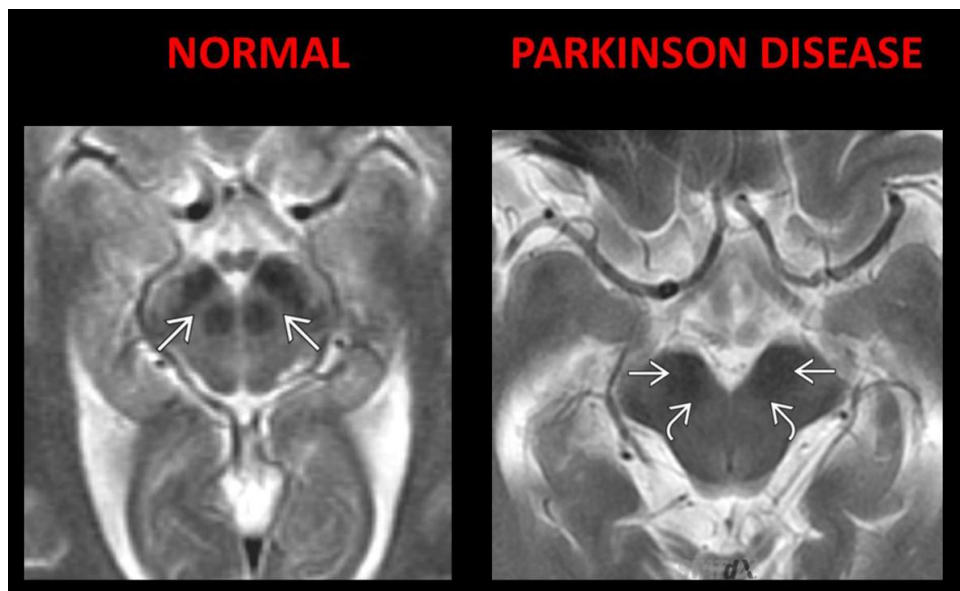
Axial T2 MR images compare normal midbrain with Parkinson disease's midbrain.
